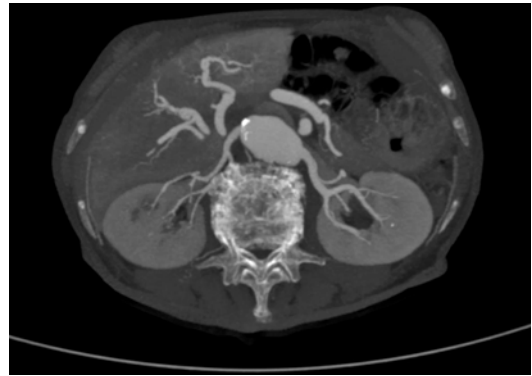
Normal renal CT angiography
